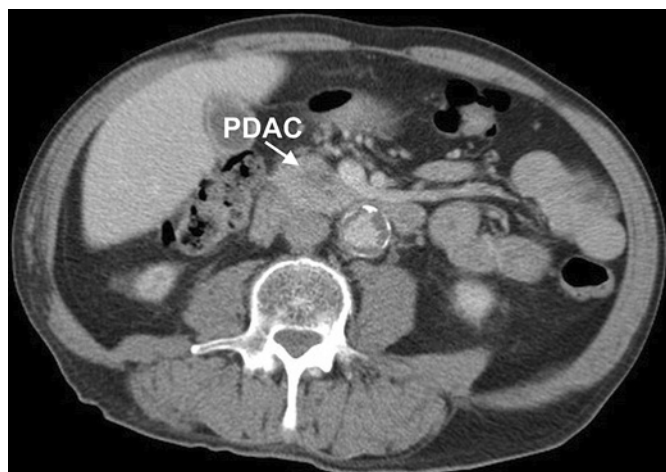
CT scan of locally advanced pancreatic ductal adenocarcinoma (PDAC) of the pancreatic body with infiltration of the celiac trunk
